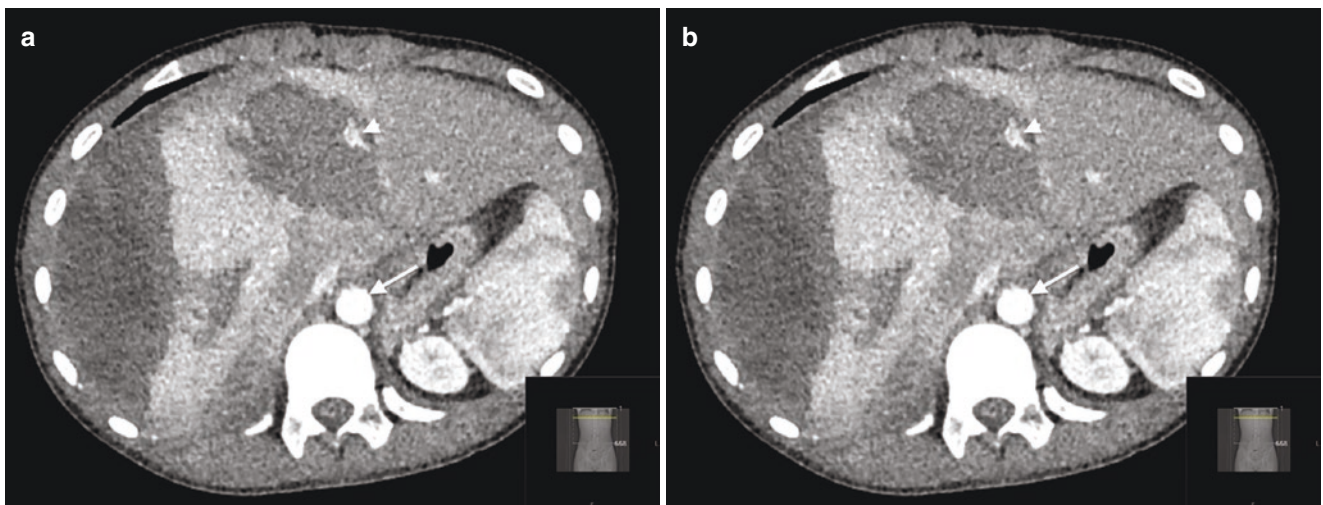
A dual-phase CT scan performed 5 days following a liver trauma demonstrates a pseudoaneurysm. (a) Roundish extravasation of contrast-enhanced blood (*arrowhead*) in the arterial phase and has a
